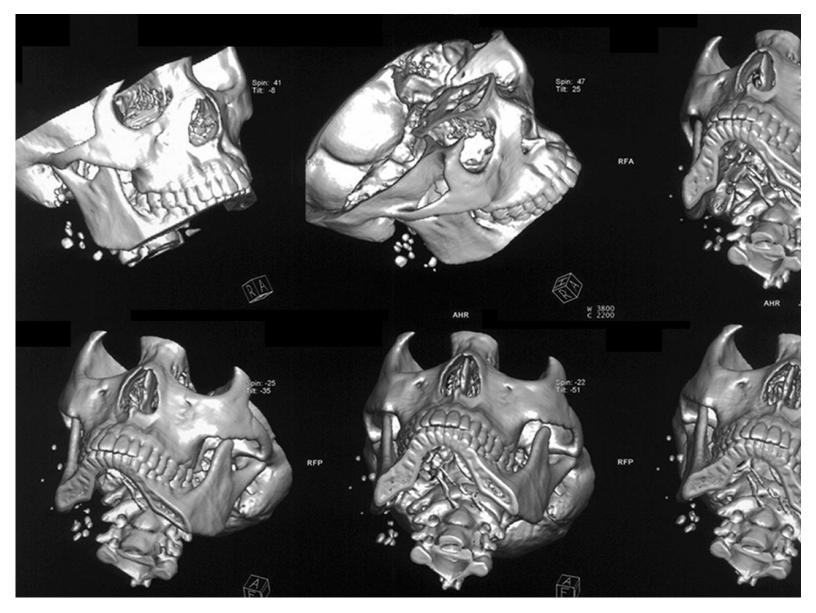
Three-dimensional reconstruction of CT of the patient. A number of high-density calcifications (2.5 mm \times 2.0 mm \times 1.5 mm) located in the parotid gland, the posterior auricular region and the submandibular region in the right maxillofacial region.
